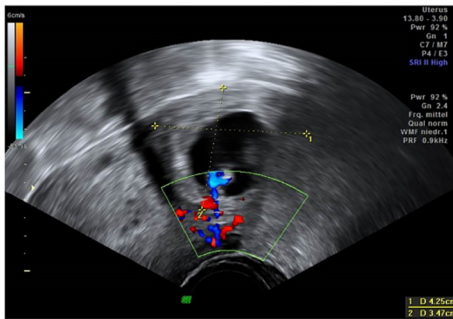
Transvaginal scan showing the size of the iEP and color Doppler.
